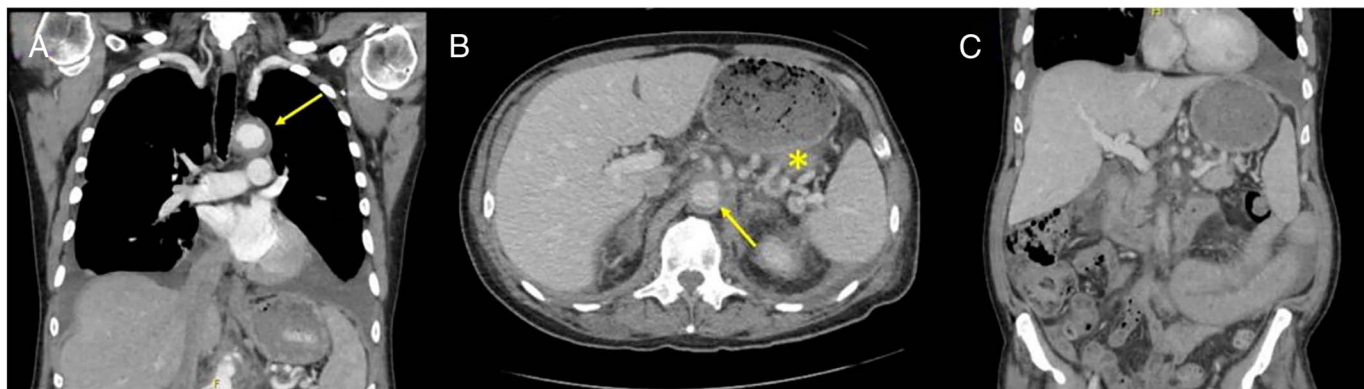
(A) Coronal view of chest computed tomography (CT) showing a thickened aortic arch. (B) Axial view of abdominal CT after paracentesis showing the thickened abdominal aorta (arrow) consistent with vasculitis and portosystemic collaterals (asterisk). (C) Coronal view of abdominal CT showing the patent portal vein and presence of portosystemic collaterals.
